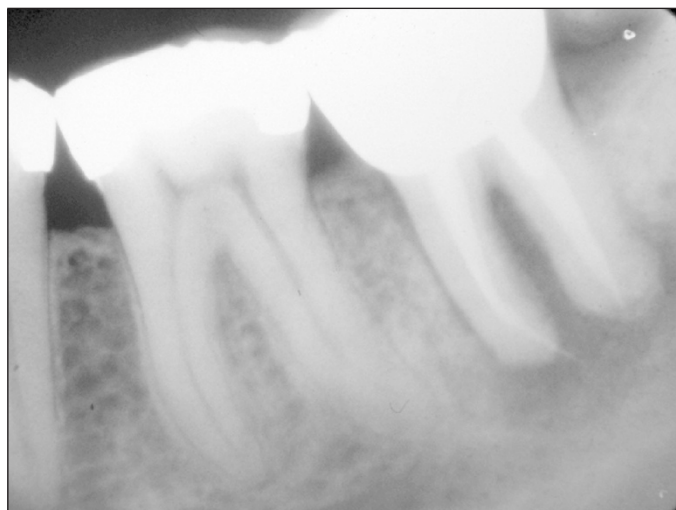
A radiograph of tooth LL7 (37) showing a root canal treatment carried out 12 months previously, with what appears to be an effective obturation yet no evidence of healing of the periradicular lesion.
